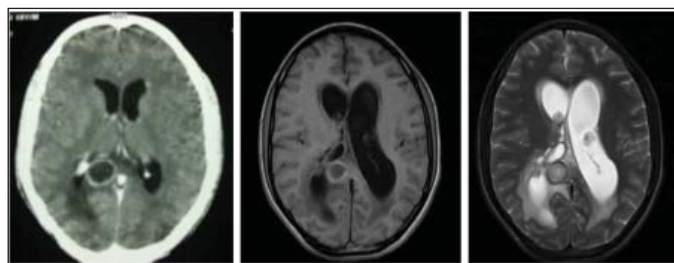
CECT image showing rim enhancing tuberculoma in splenium with corresponding T1W and T2W MRI images
